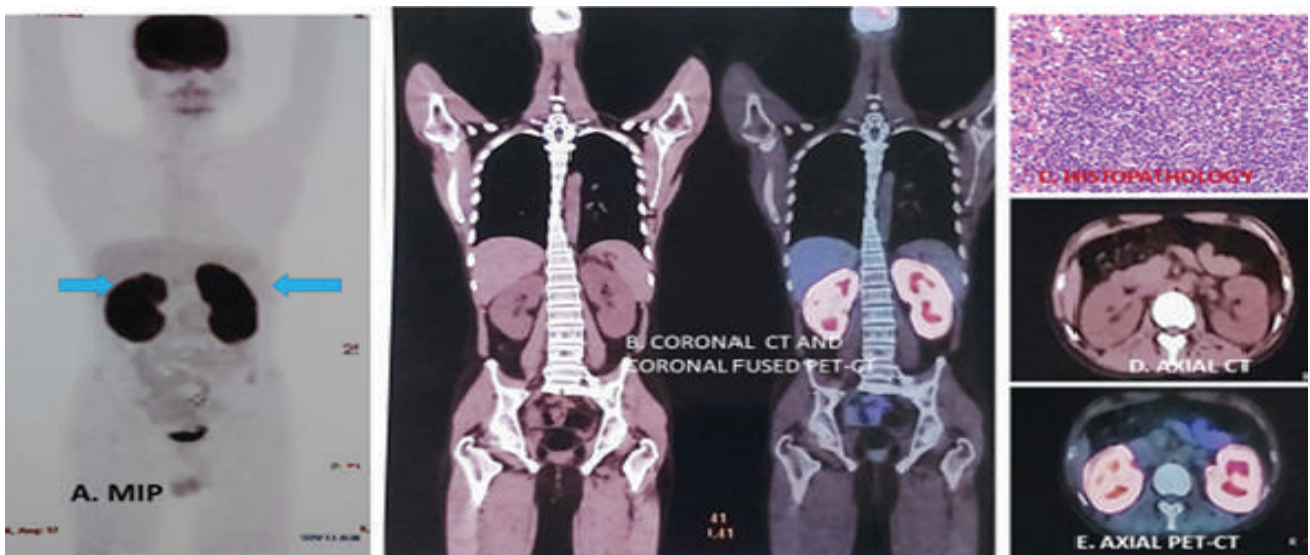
Primary extranodal lymphoma of intermediate grade NHL involving both the Kidneys in a male patient presented with hematuria. FDG PET-CT showed mild enlargement of both kidneys with intense and diffuse FDG uptake (SUVmax:20) (A, B, E), no definite mass in CT (B, D). No other hypermetabolic visceral, nodal or skeletal lesion.
